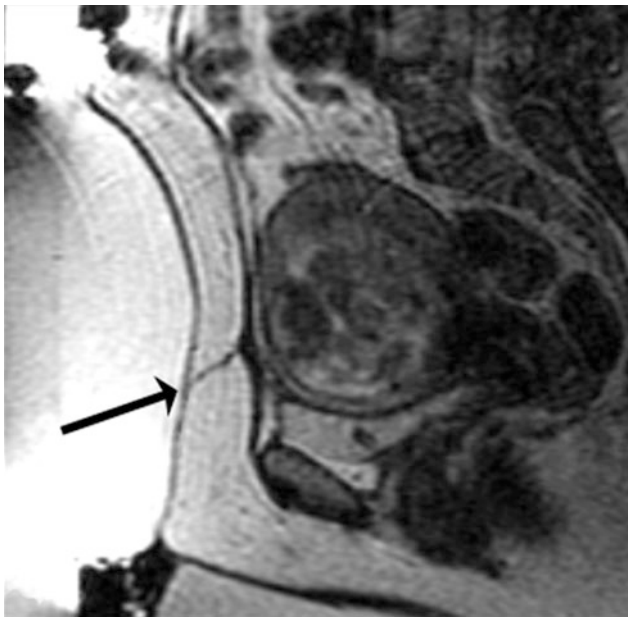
Screening MRI demonstrates a scar (*arrow*) from a previous Caesarian section. This scar is directly in the path of the ultrasound beam. Treating in the vicinity of a scar may lead to severe burns and is a contraindication for MRgFUS treatment
